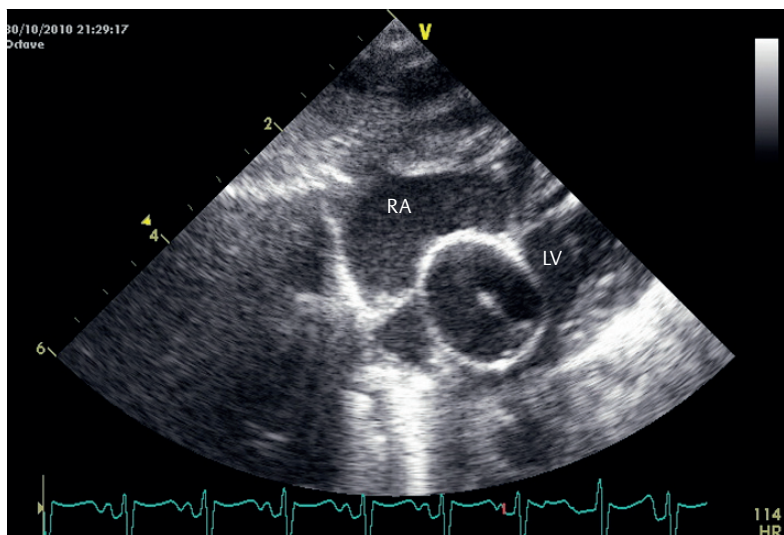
Echocardiogram with balloon septostomy.
